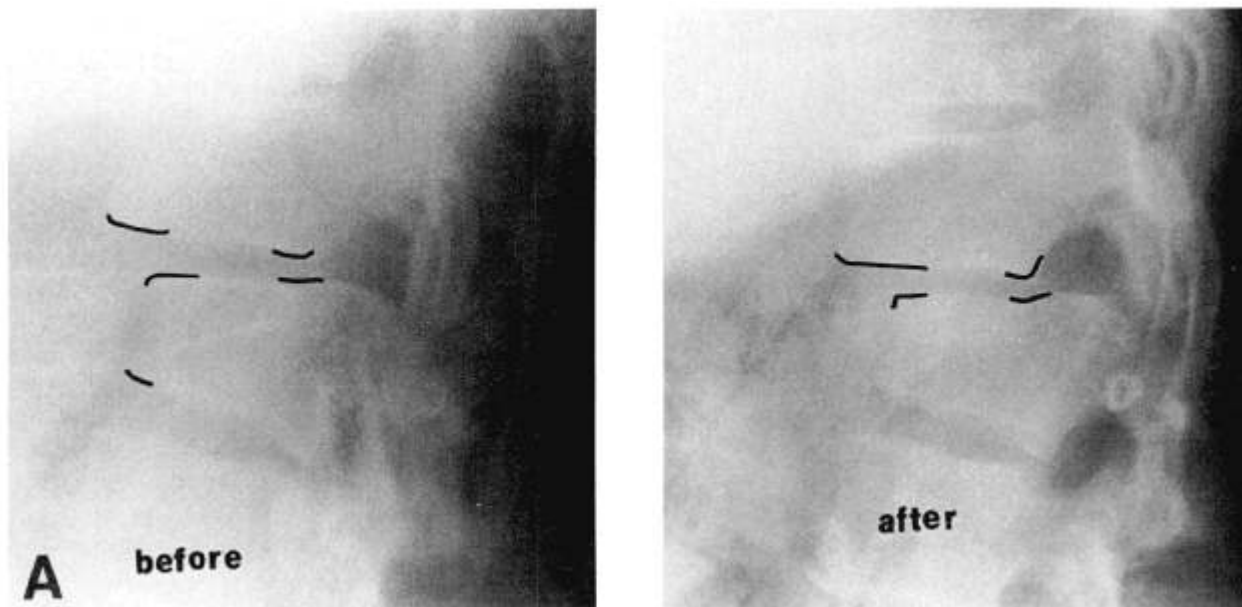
Analysis of the radiographs in turning the patient from supine to the lateral position revealed no AP displacement.
